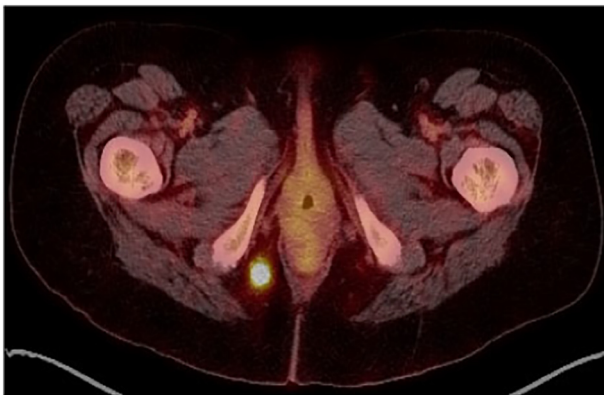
PET scan of pelvis showing FDG avid in the right ischioirectal fossa nodule.
